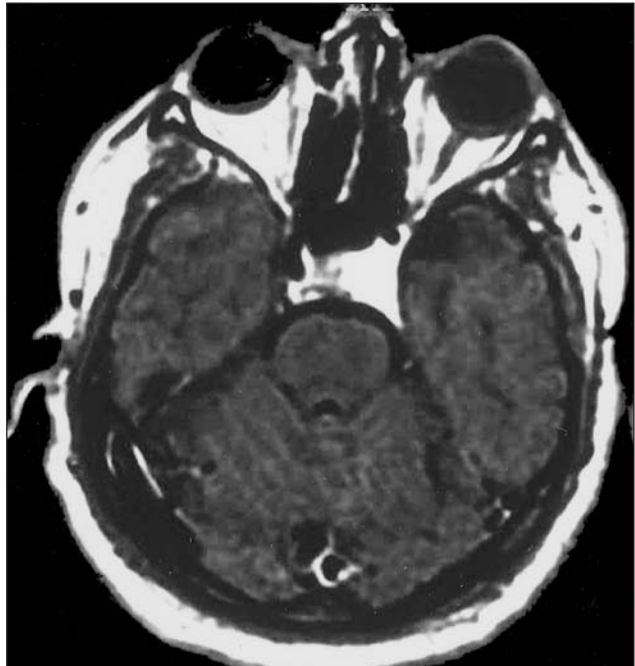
Case 2: Postoperative T1-weighted contrast axial MRI shows residual tumoral mass on the left temporal lobe related with cavernous sinus, two years after the operation.
